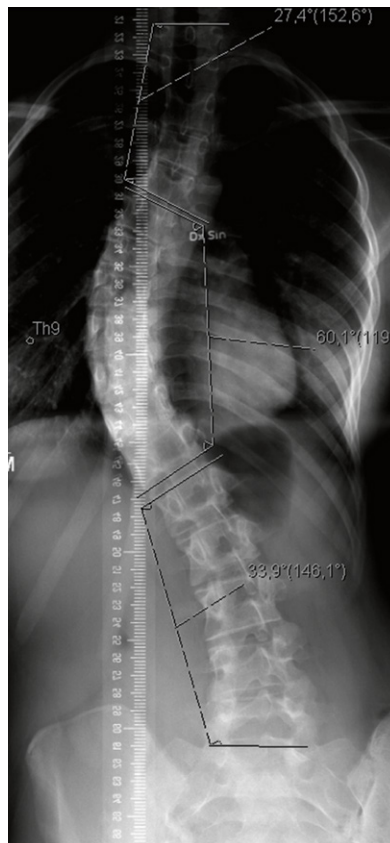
An example of a frontal radiograph of a scoliotic spine. Included in the image are measurements of the Cobb angle.
